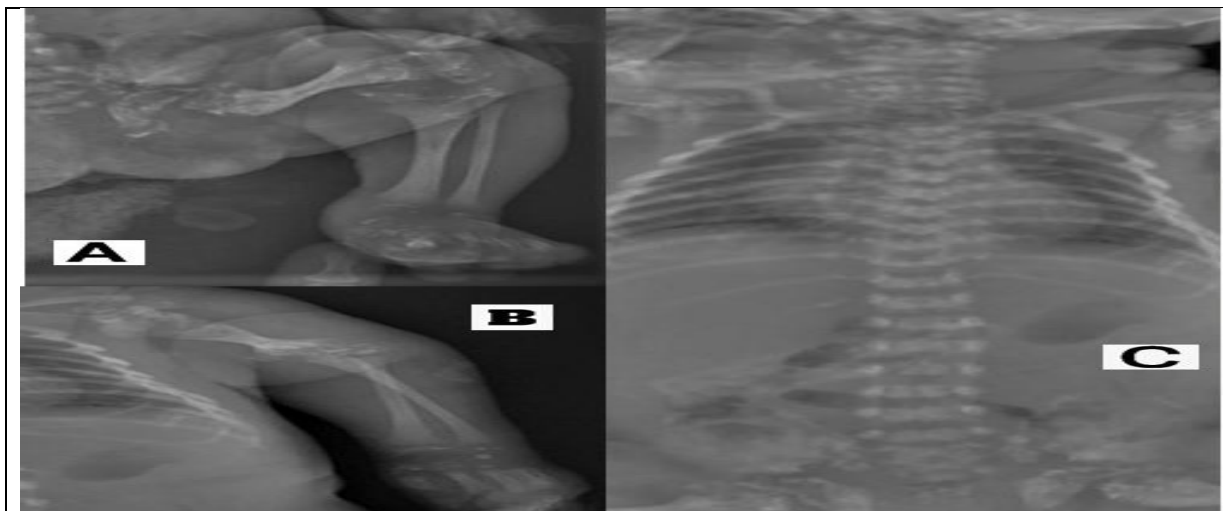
Chondrodysplasia Punctata. (A,B) Upper and lower limb x-rays shows stippling of epiphysis in all large joint. (C) Cropped part of infantogram showing coronal cleft in the vertebral bodies. Note the absence of stippling in the vertebral bodies, hands and feet.
